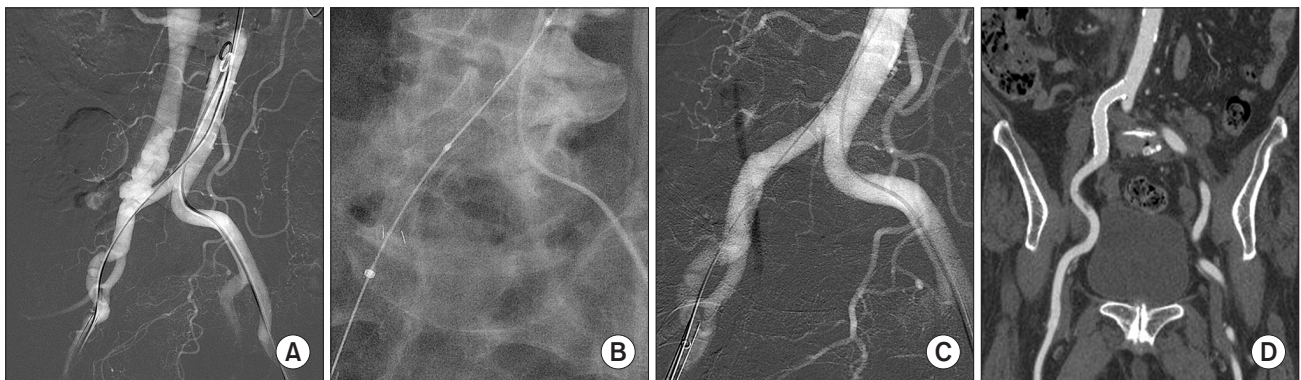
(A) Sixty months after discectomy, angiography shows arteriovenous fistula between the right common iliac artery (CIA) and vein. (B) Covered stent deployment was performed. (C) Completion angiography showed no fistula between the right CIA and vein. (D) Two months after intervention, follow-up computed tomography shows no evidence of fistula.
